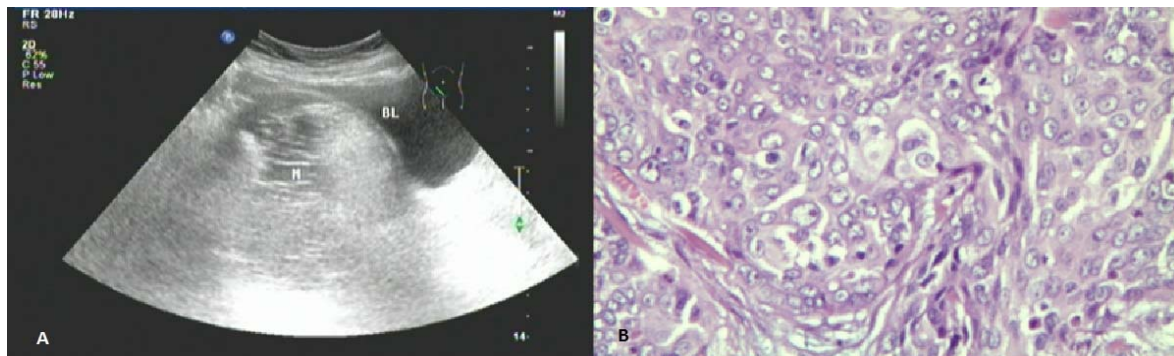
Ultrasonography (A) and pathological (B) analysis of a pelvic mass detected in a 24-year-old patient.
